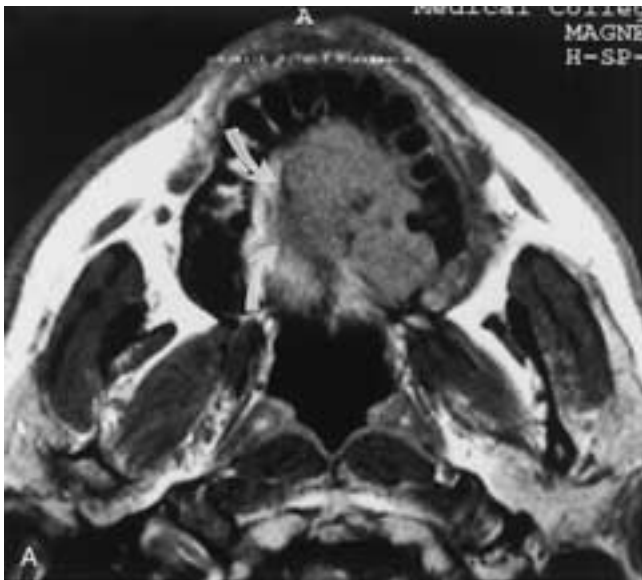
Adenocarcinoma of the left hard palate. A, T1-weighted axial MR image demonstrates a large lesion destroying the left hard palate, filling the left maxillary sinus, and extending across to involve the contralateral side (*arrows*). There was infiltration of the palatal mucosa despite apparent preservation of cortex. B, Axial T2-weighted MR image on a higher plane at the maxillary sinus level reveals an inhomogeneous appearance with some solid and cystic areas. C, Contrast-enhanced T1-weighted image in the coronal plane demonstrates significant tumor enhancement. Note the enhancement of the infiltrated palatal mucosa (*arrows* in C).
